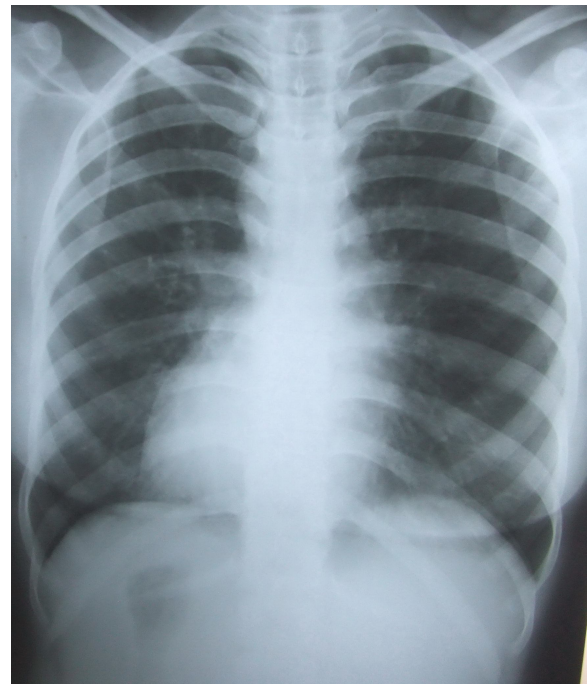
Dextrocardia showing on X-Ray Chest
